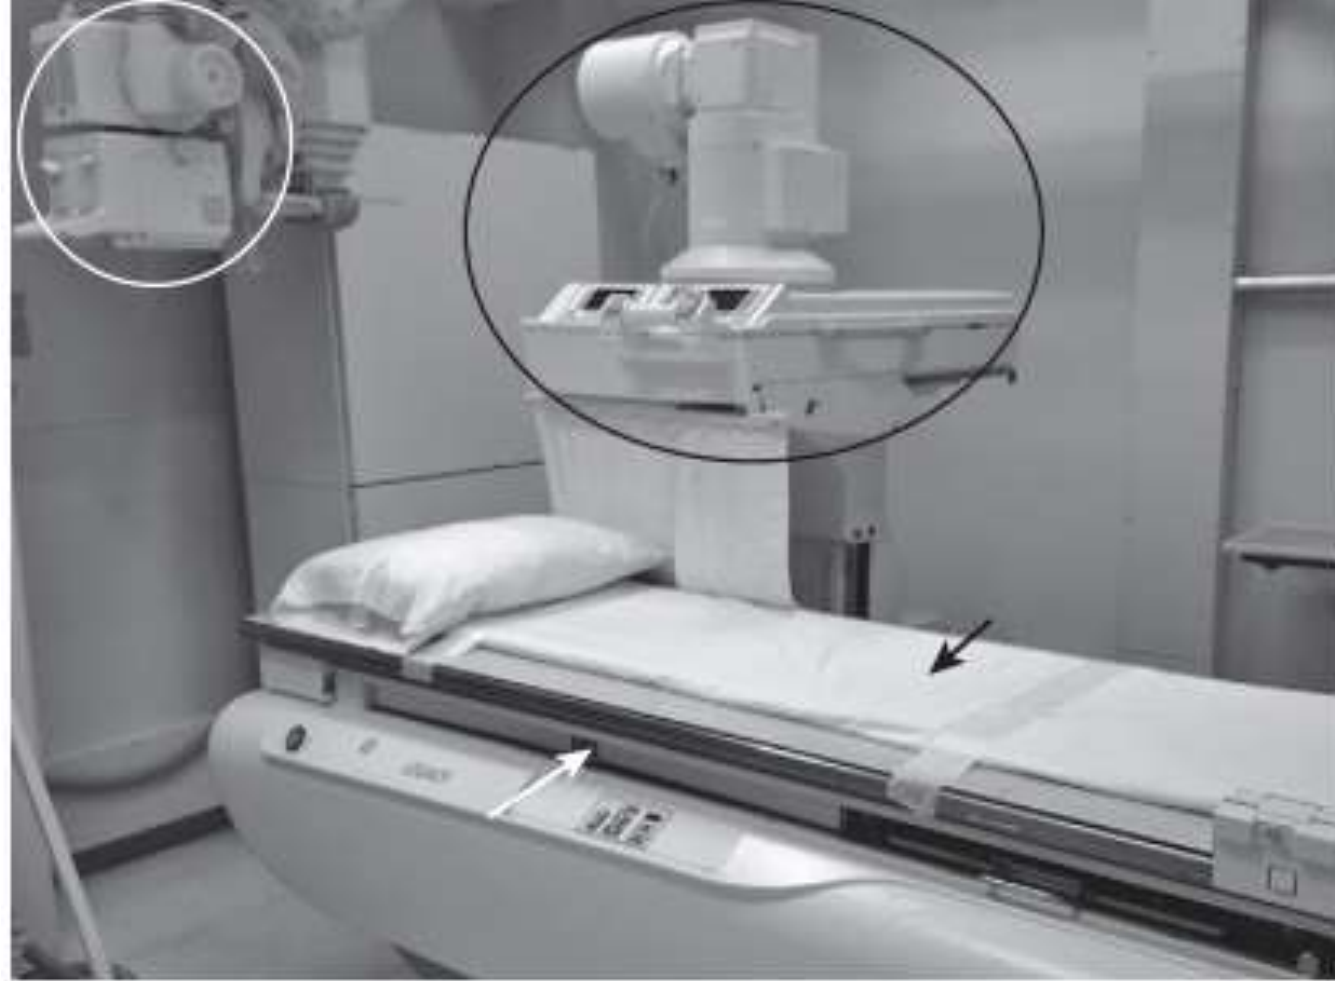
A standard radiology room equipped for both conventional radiography and fluoroscopy. The patient lies on the table (*black arrow*), which has the capacity to tilt up or down. Images can be obtained using the tube on the fluoroscopic carriage (*black oval*), which can be moved over the patient by the operator and then manipulated more or less freely to follow the barium column. Static images can be obtained using the overhead x-ray tube (*white circle*). The x-ray tube can be moved into place over an x-ray cassette, which would be located under the patient (*white arrow*).
